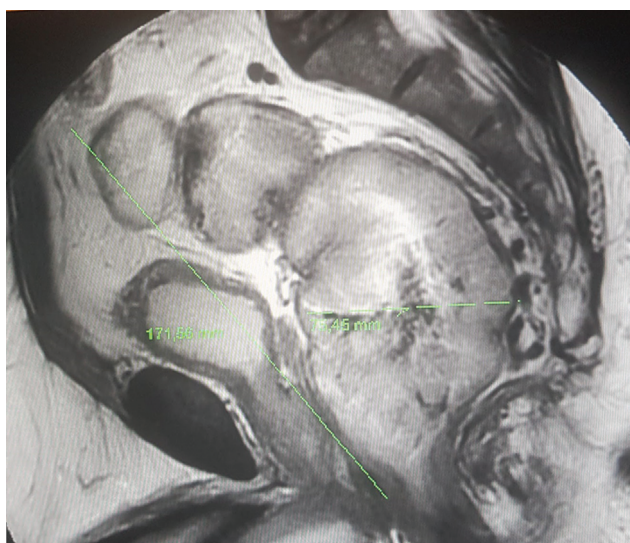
Magnetic resonance imaging, sagittal view. Image suggestive of neoplastic process of 17.1 × 7.5 cm.
